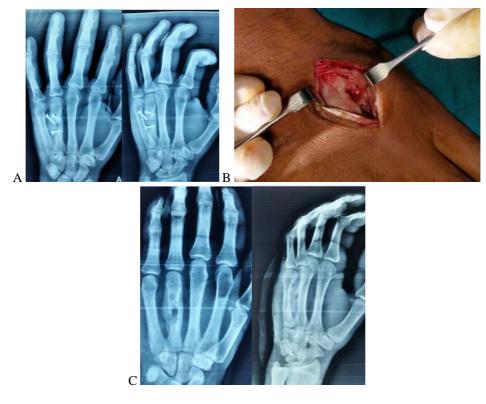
(a) Nine weeks post operative plain X-ray of fourth metacarpal fracture fixed by three screws showing screws lossning due to infection (b) removal of screws and sequestrectomy (c) plain X-ray after screws removal
